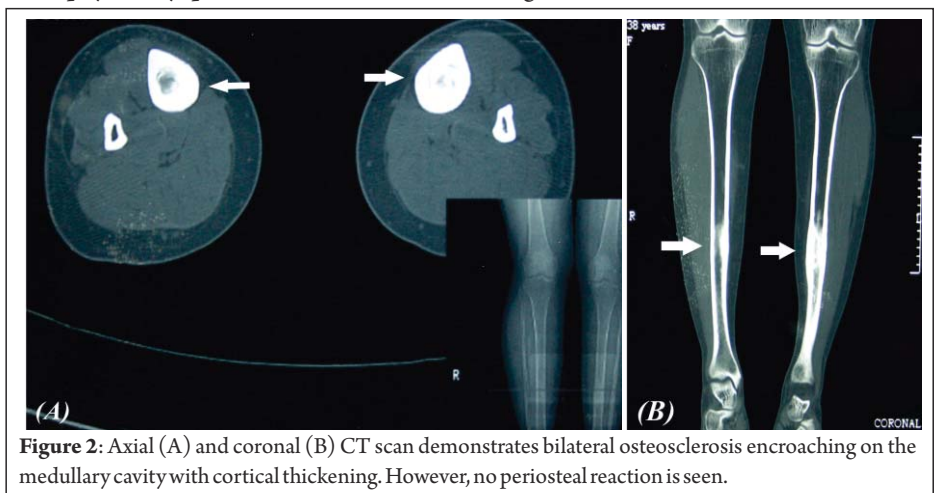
Axial (A) and coronal (B) CT scan demonstrates bilateral osteosclerosis encroaching on the medullary cavity with cortical thickening. However, no periosteal reaction is seen.
